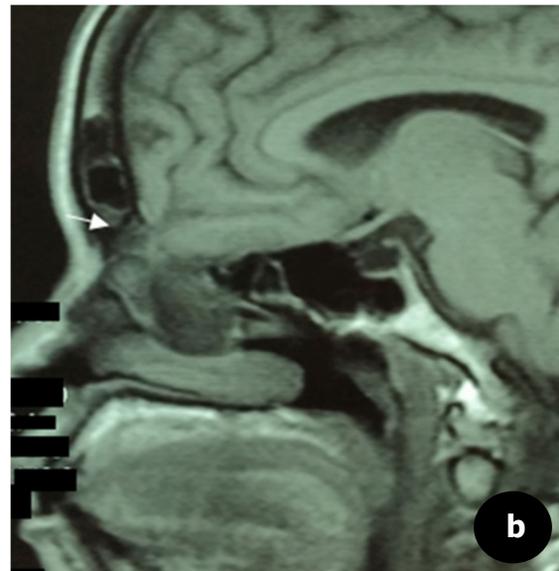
MRI (Sagittal T2) of the head
